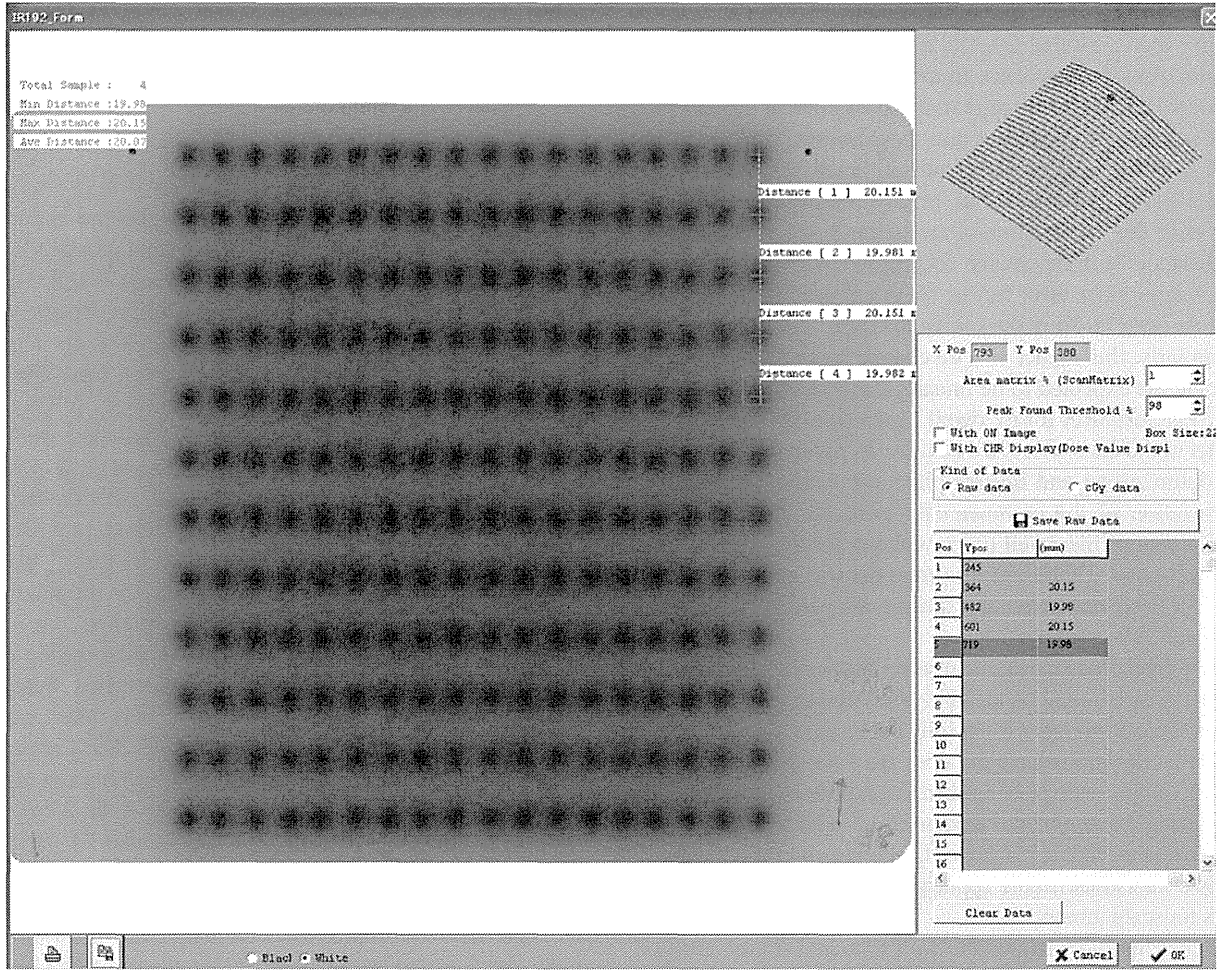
Radiographic film EDR2 (Carestream Health Inc.) was analyzed for the measurement of source position accuracy using film QA software DD-system Ver. 10.21 (R-TECH Company).
